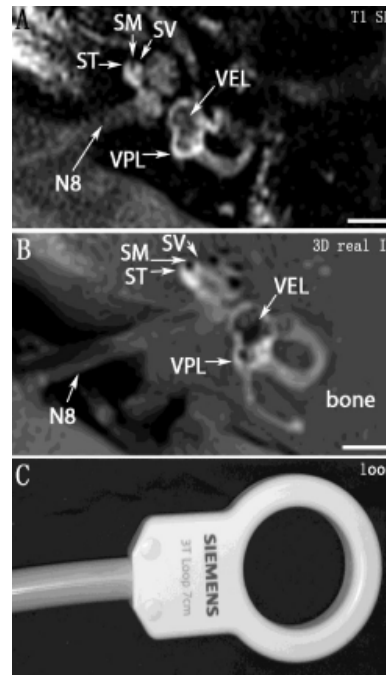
Three Tesla MR imaging with a hybrid of a 16 channel head coil and an ear surface coil (loop 7 cm) after intra-tympanic administration of Gd-DOTA [138] in a patient with left ear Menière's disease. A: T1-weighted Spin Echo, B: 3D real IR. C: An additional loop coil was utilized. N8: 8th cranial Nerve; SM: Scala Media; ST: Scala Tympani; SV: Scalavestibuli; VEL: Vestibular Endolymph; VPL: Vestibular Perilymph. Scale bar = 5 mm [138].
